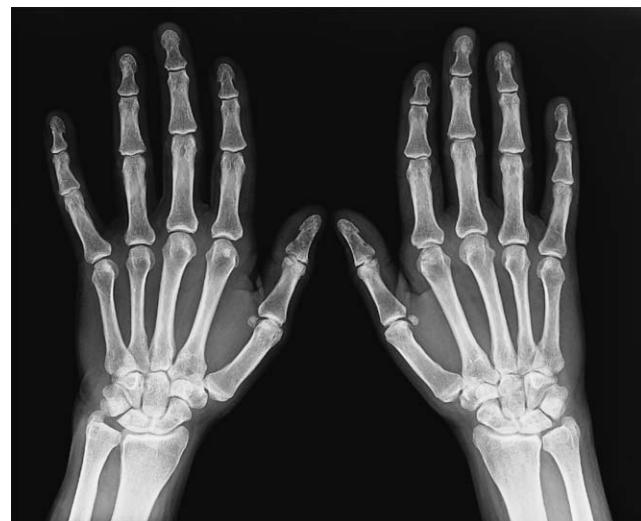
Symmetric non-erosive arthritis of the small joints of the hands on a plain radiograph
